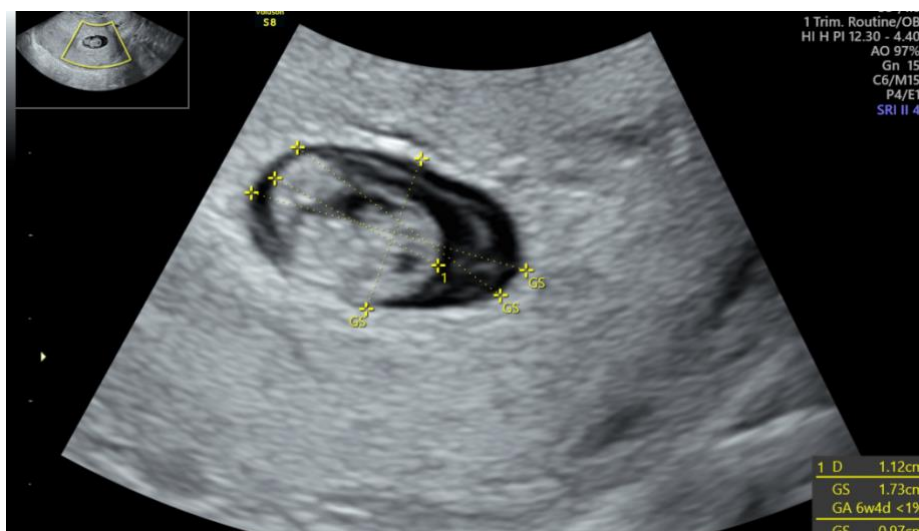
Transvaginal ultrasound at 8+3 weeks of gestation demonstrating measurement of crown–rump length (CRL) and mean gestational sac diameter (GS)
